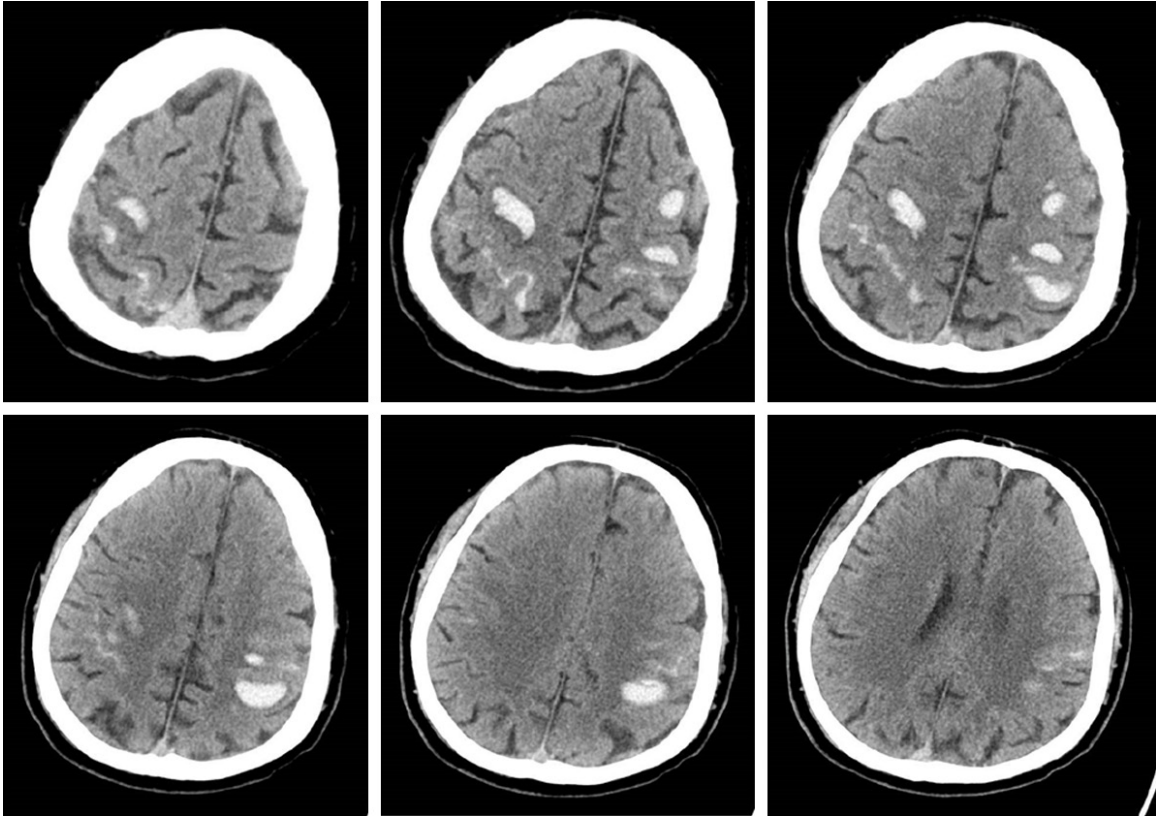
A brain CT scan showed multiple high-density lesions in the bilateral frontal and parietal lobes, and linear high-density lesions were seen in the sulcus of the bilateral frontal and parietal lobes.
